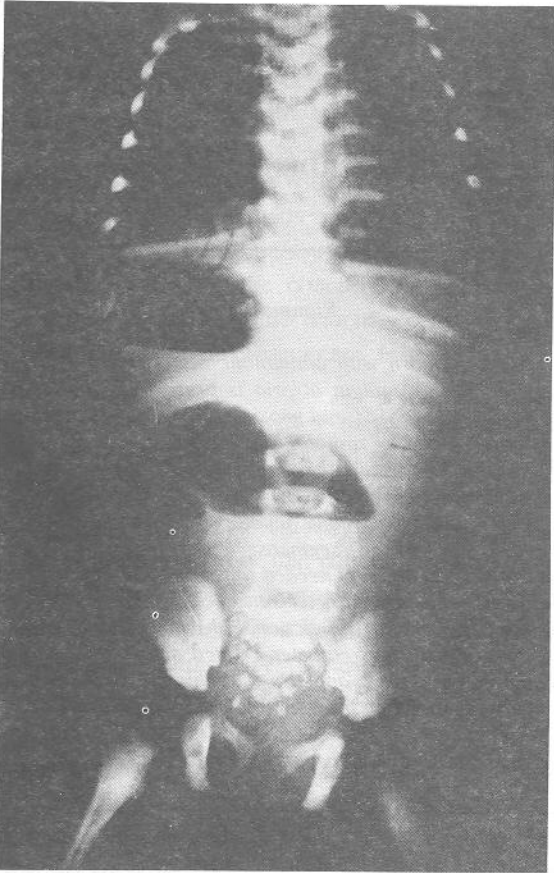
Plain upright abdominal and chest X-ray confirming proximal intestinal obstruction and partial situs inversus.
